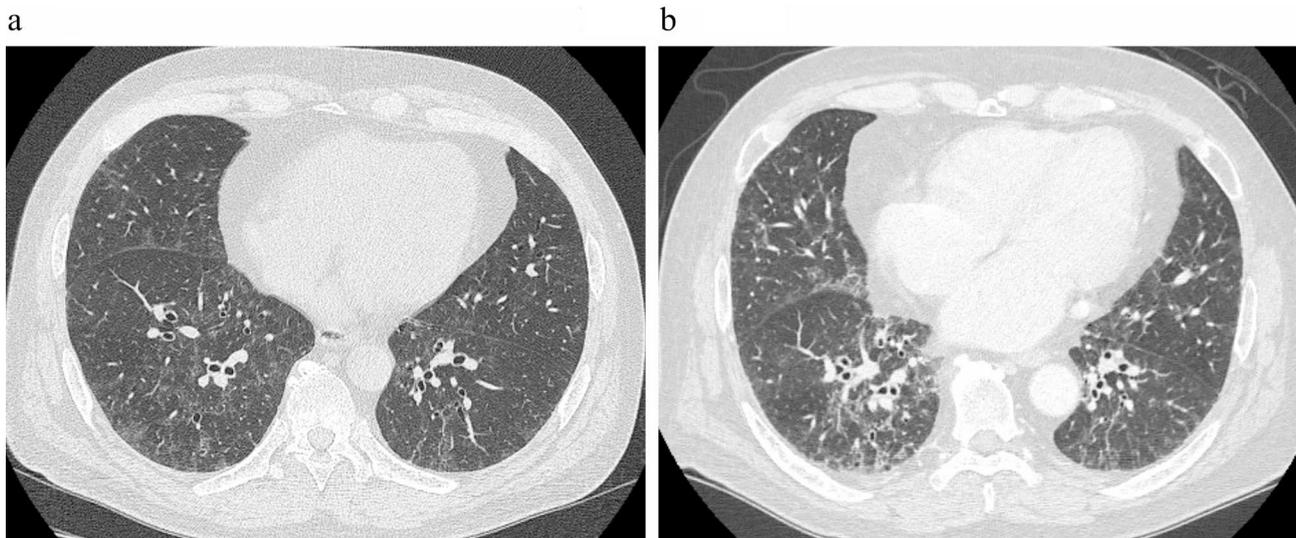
CT images of ILD in a 49-year-old man. (a) When he was diagnosed with psoriasis vulgaris at 49 years old. The ground glass opacities are observed, mainly in the bilateral lower lobes. (b) Twelve years later, at age 61. ILD has progressed and is accompanied by decreased air volume in the lower lobes
